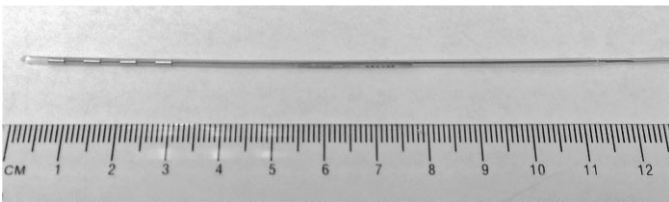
The wirelessly powered lead used for SCS that underwent testing for MRI issues: photograph.
